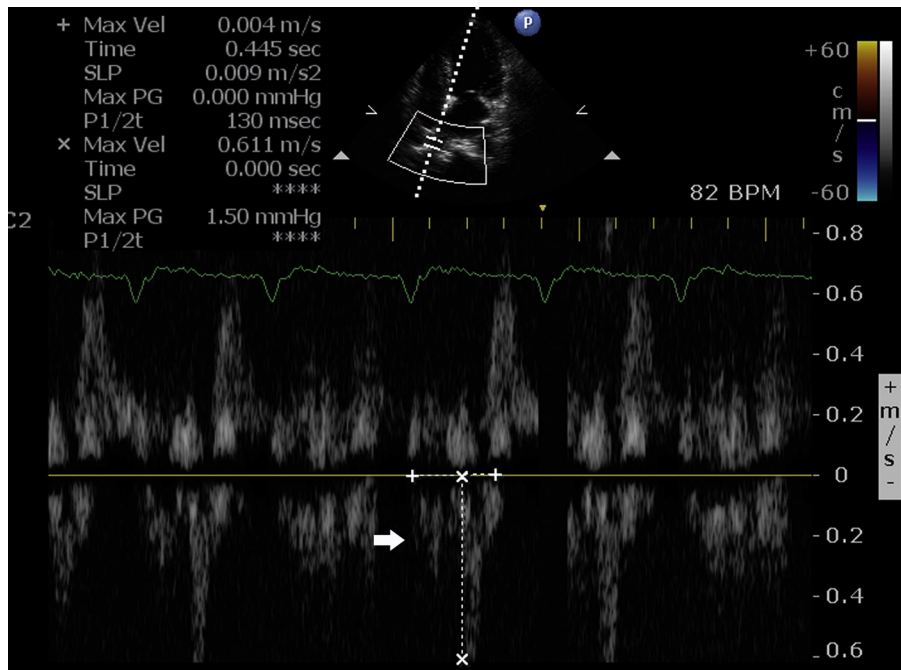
Pulmonary venous Doppler showing prominent 'a' reversal.
